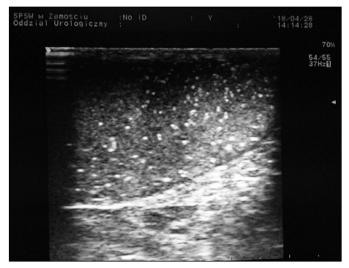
Ultrasonographic image of testicular microlithiasis (28-year-old infertile man).
